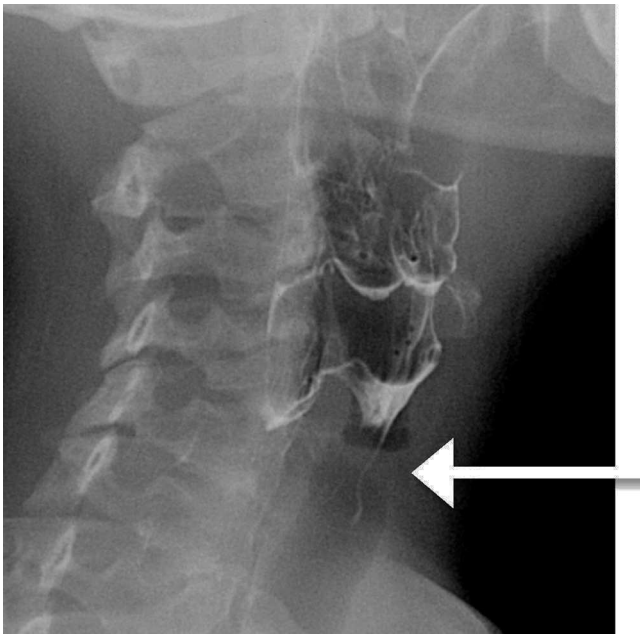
Barium X-ray examination showing a fistula tract from the hypopharynx to the thyroid gland.
